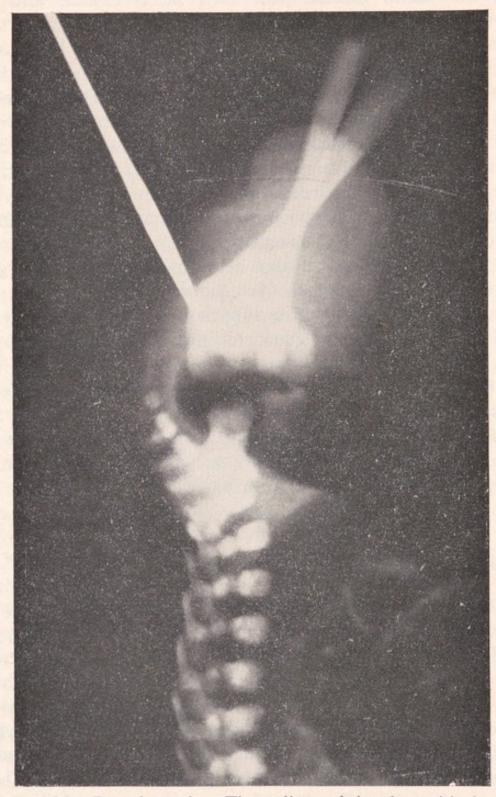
Rectal atresia. The radiograph is taken with the infant inverted. The tip of the forceps indicates the site of the anal dimple. (By courtesy of Mr. P. P. Rickham.)
